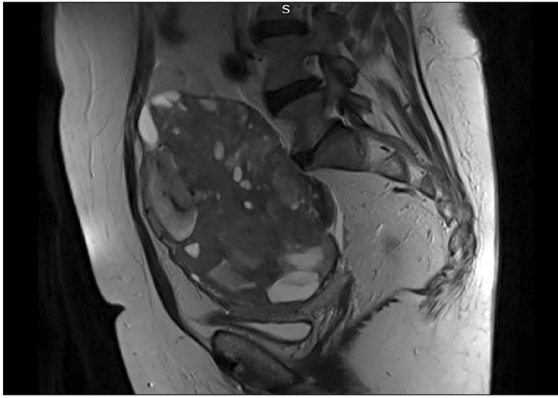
MRI scan of the tumor (sagittal)
